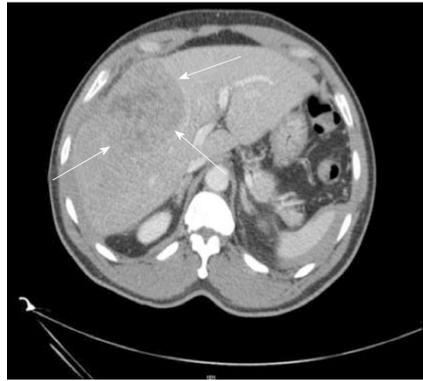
Computed tomography image of a 64-yr-old male with hepatitis B. No cirrhosis found to have large 9 cm mass in right lobe (arrows) on CT abdomen done for abdominal pain.
